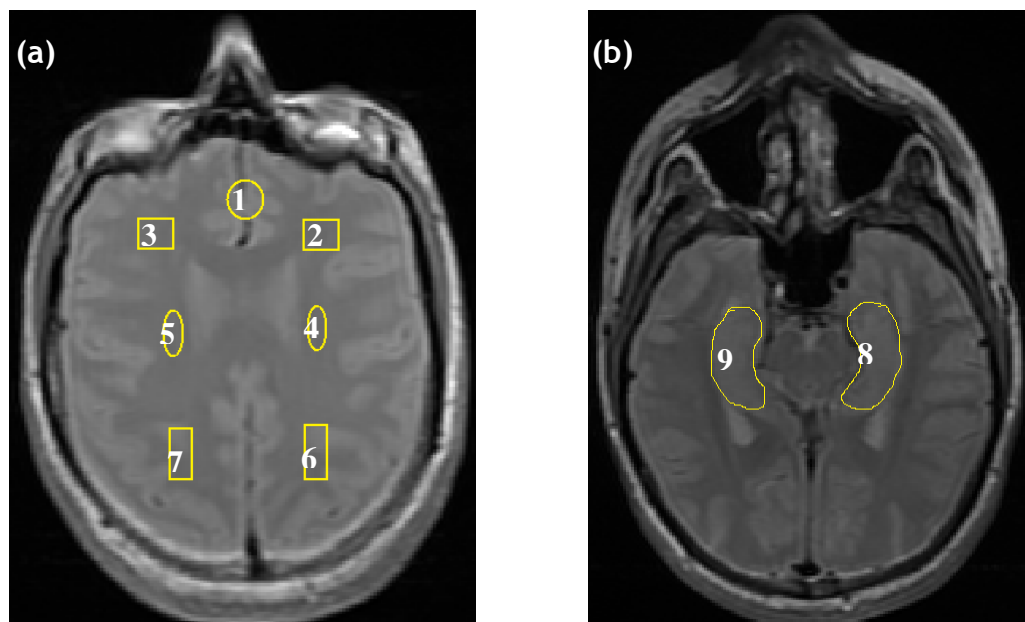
T_2 -weighted MRI scan of an axial slice through the prefrontal brain region (a) and the bilateral hippocampi (b) in a healthy volunteer.
